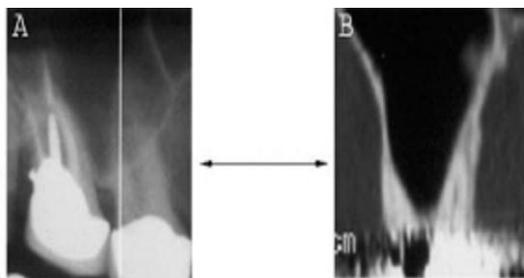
Radiographic images of roots projecting on the sinus cavity in the panoramic radiograph, but only lateral to the sinus in the CT image. A, section of the panoramic radiograph showing classification 3 for the 1<sup>st</sup> molar roots, (marked longitudinal white line indicates the location of the cross-sectional image of the CT). B, cross-sectional image showing classification 2 for the same tooth.
